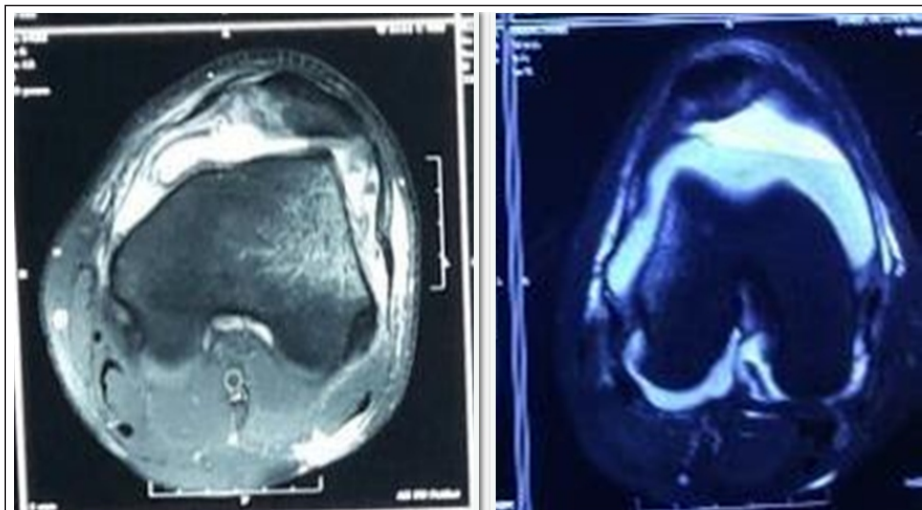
(a) Pre-operative MRI showing Medial Facet Osteochondral Patella Fracture with MPFL Avulsed from Femoral Site. (b) Pre-operative MRI showing Medial Facet Chondral Patella Fracture with no MPFL injury.
